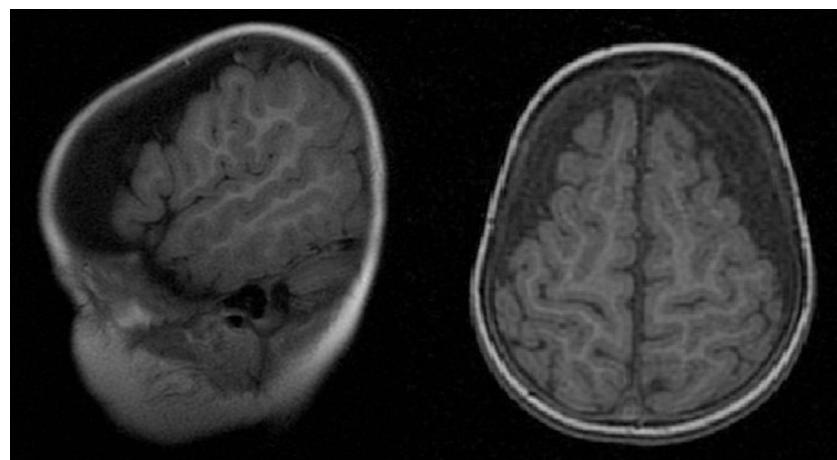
Sagittal and axial plane from brain MRI (T1-weighted sequence).
